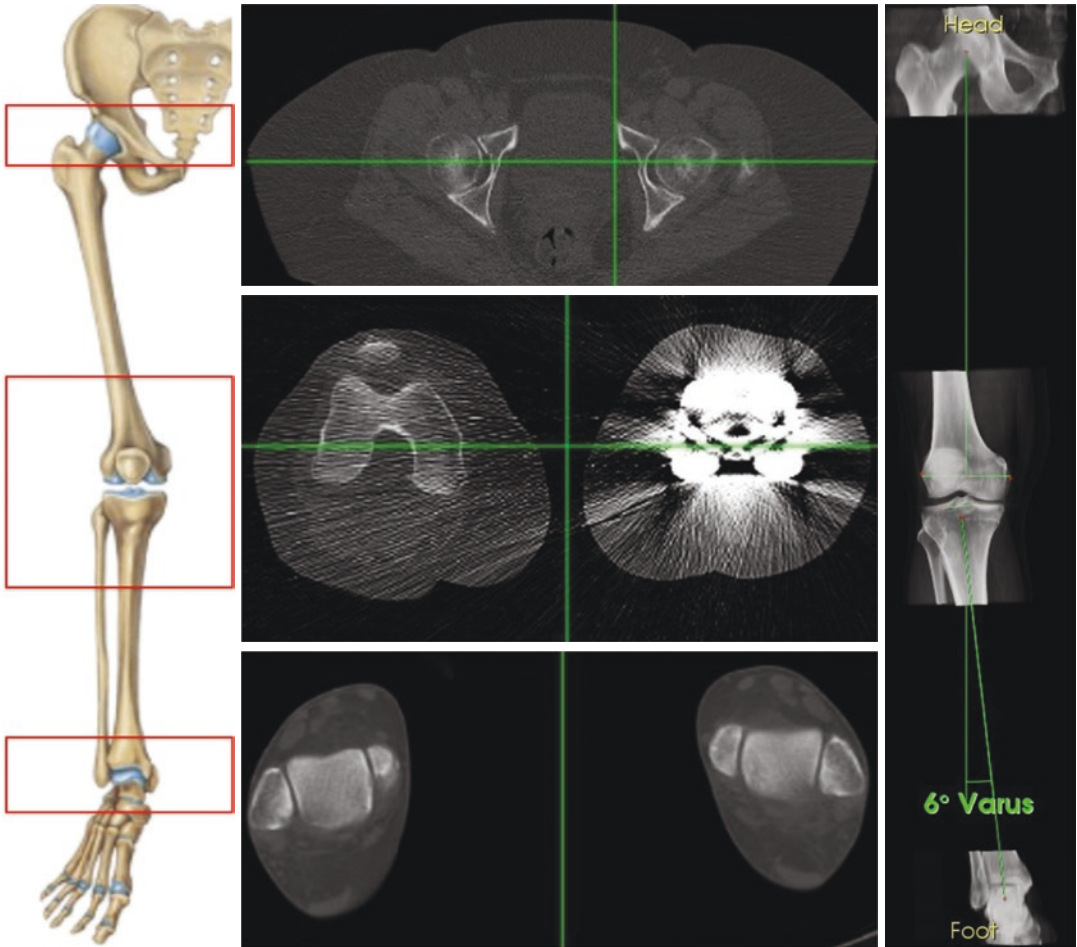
The modified imperial knee CT protocol: reduced slice thickness (3 mm) for hip and ankle, regular slice thickness for knee (7 mm)
